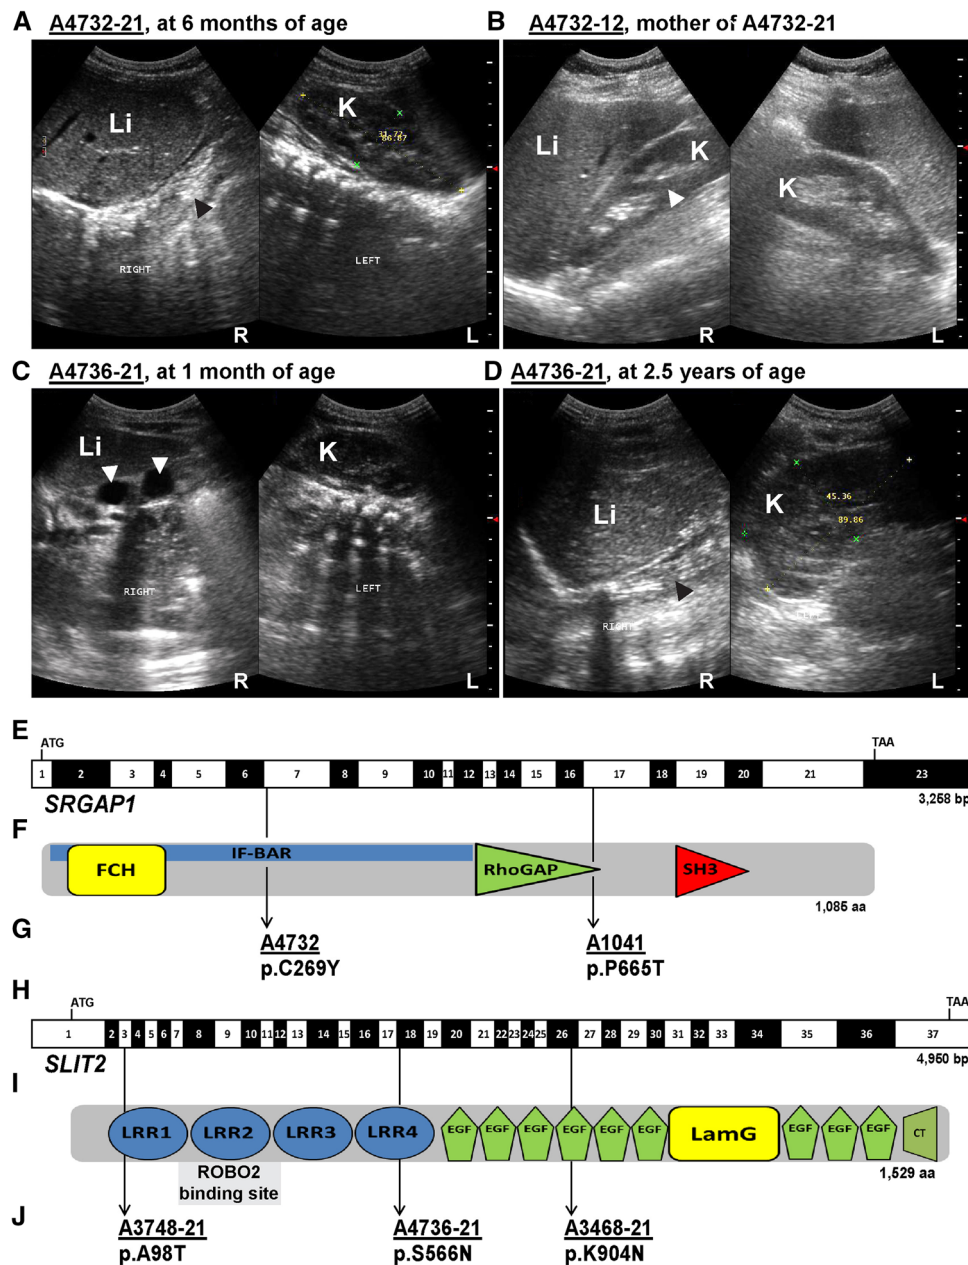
Ultrasonographic findings in two families with CAKUT and localization of newly identified mutations in *SRGAP1* and *SLIT2* cDNAs and proteins. a Renal ultrasonography of individual A4732-21 at age 6 months (*SRGAP1* mutation) showing absence of renal tissue on the *right side* (black arrowhead) at the expected location adjacent to the liver (*Li*). The left kidney (*K*) shows compensatory hypertrophy. Prenatally, right multicystic dysplastic kidney (MCDK) was diagnosed (not shown). b Renal ultrasonography of the patient's mother (*SRGAP1* mutation) showing separation of the central echogenic complex in the right kidney (white arrowhead) indicating a non-obstructive duplex kidney. The left kidney is normal. c MCDK on the *right side* in individual A4736-21 (*SLIT2* mutation) at age 3 months (white arrowheads denote two large cysts). d In the same individual, at age 2.5 years, no renal tissue was detectable on ultrasound on the right (black arrowhead), indicating complete involution
